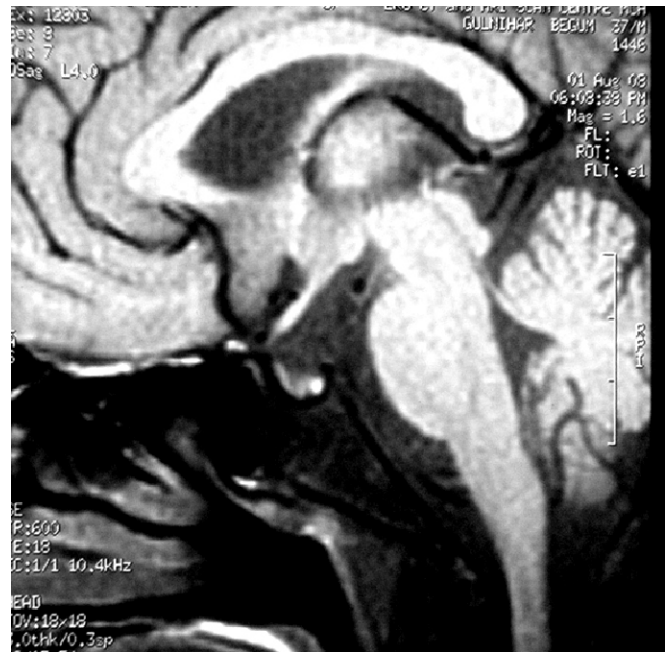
MRI of the pituitary showing partially empty sella.
